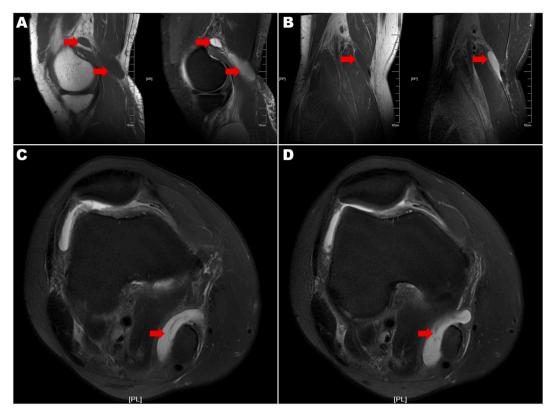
Knee MRI (A-D) clearly delineating the location and size of the popliteal cyst.
